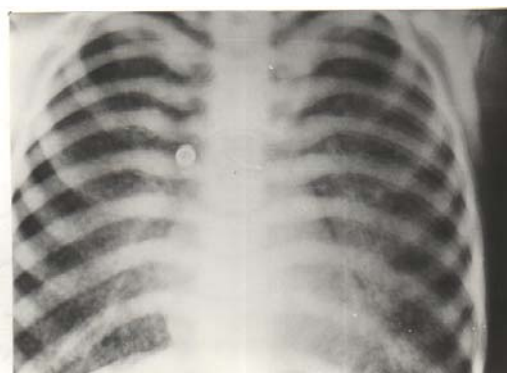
Chest x-ray shows bilateral diffuse micronodular calcified densities and high density ribs.
